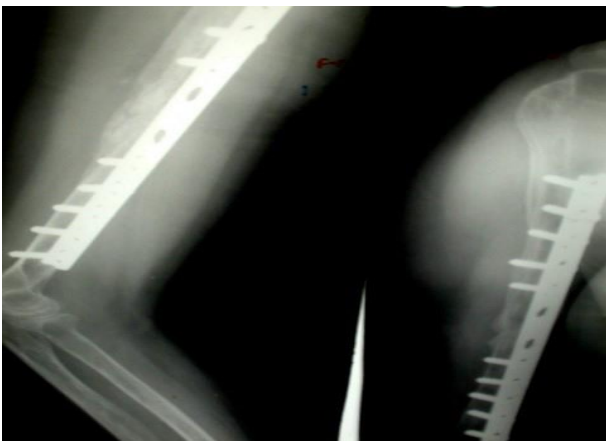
X-ray of good union 2 years after plating and allografting.
